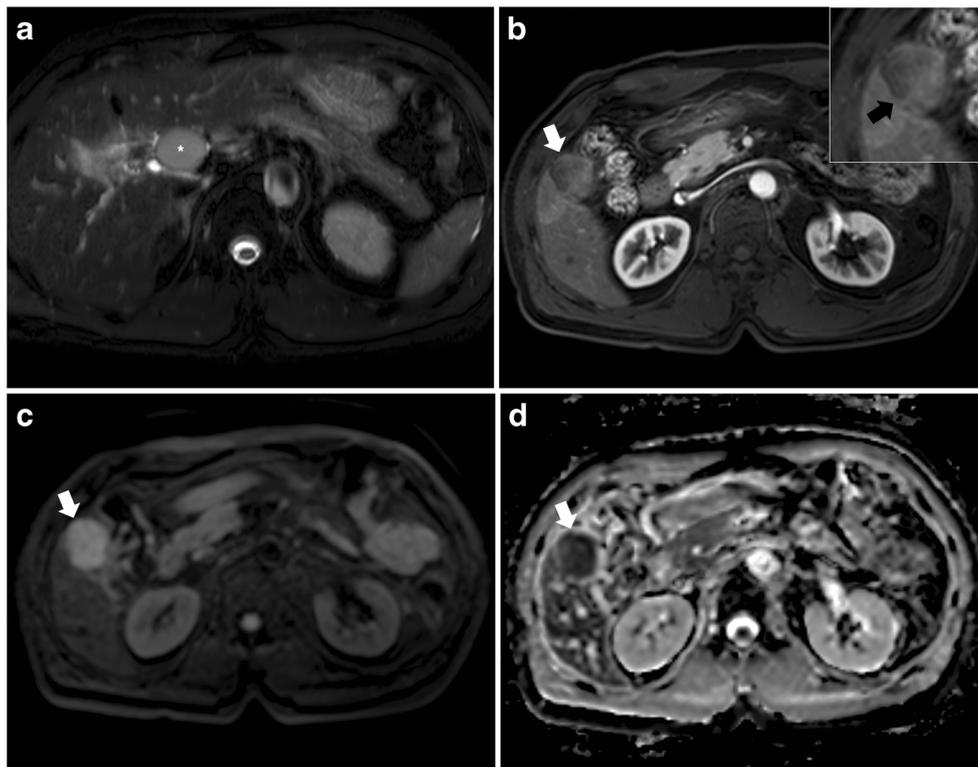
Images of a 56-year-old man with a poorly differentiated adenocarcinoma of the gallbladder. a On the T2-weighted axial MR image, a well-defined nodular lesion with high signal intensity (asterisk) is seen as a metastatic lymph node around the hepatoduodenal ligament. b On the portal phase, gallbladder fundus is filled with a 4-cm mass (white arrow). There is pericholecystic infiltration around the gallbladder bed with direct
